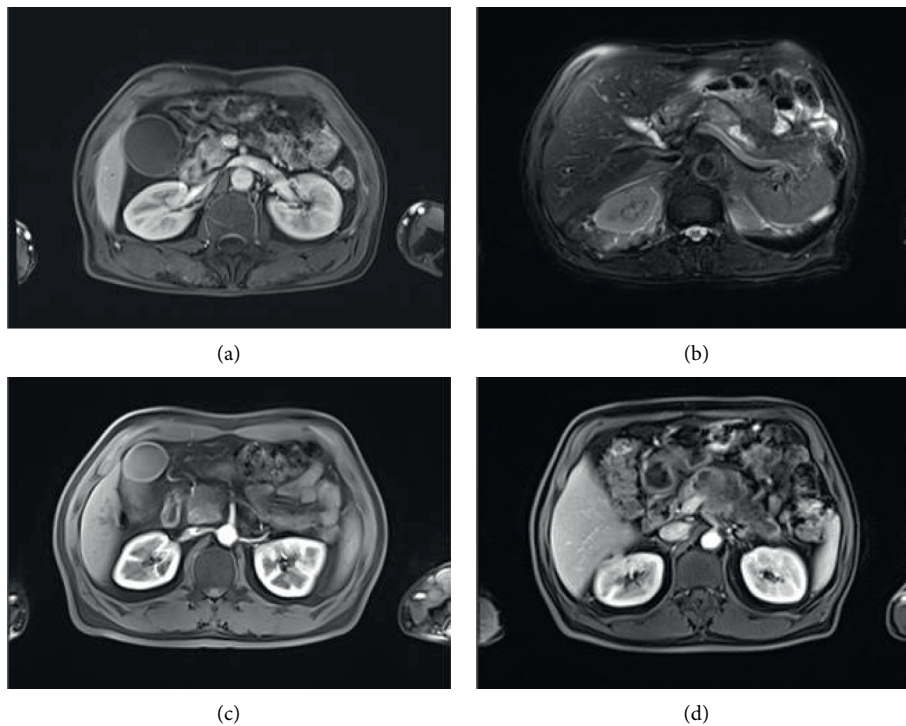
MRI images of patients with PC. (a) PC stage I: there is a nodular, slightly longer  $T_1$  shadow in the head of the pancreas, about 10 mm in diameter, with delayed enhancement and dilation of the main pancreatic duct. (b) PC stage II: there was a long  $T_1$  and  $T_2$  signal shadow in the body of the pancreas, with obvious hyperintensity on DWI and unclear boundary,  $29 \text{ mm} \times 18 \text{ mm}$ , and enhanced scanning showed mild enhancement and distal pancreatic duct dilation. (c) PC stage III: the pancreatic head is enlarged, and the pancreatic body and tail are atrophic. In the pancreatic head area, there are lump-like long  $T_1$  signal shadows,  $43 \text{ mm} \times 40 \text{ mm}$ , and mild enhancement. (d) PC stage IV: there were lump-like long  $T_1$  shadows in the body of the pancreas, with an unclear boundary,  $40 \text{ mm} \times 85 \text{ mm}$ , the enhancement degree was lower than that of the pancreatic parenchyma on an enhanced scan, and the adjacent peritoneal trunk was surrounded in it.
